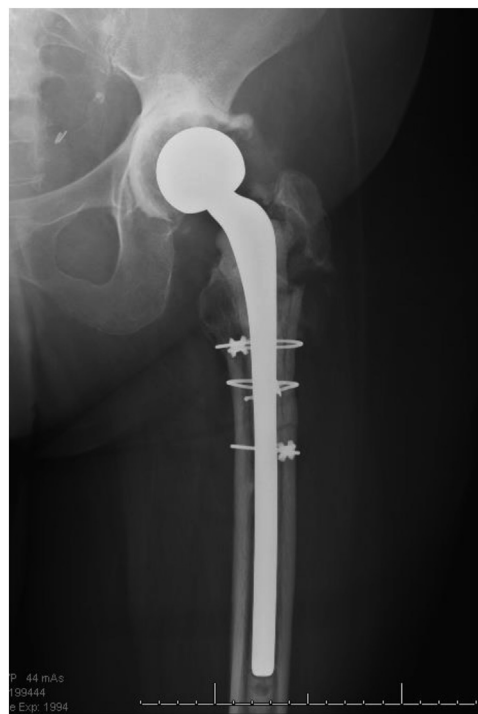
AP radiographs of the left hip after removal of components and placement of a cemented acetabular liner and Prostalac hip stem. Interval healing of extended greater trochanter osteotomy and interval displacement of greater trochanter fracture.
